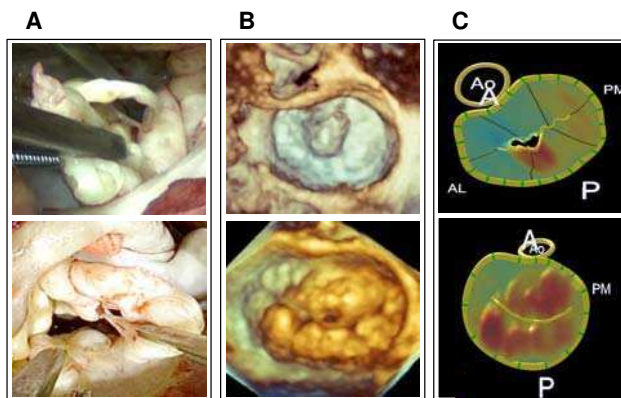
Examples of views of the mitral valve from the left atrial perspective obtained in two patients with degenerative mitral valve disease: (top) fibroelastic deficiency with a P2 flail leaflet and ruptured chords, and (bottom) Barlow's disease with multi-segmental billowing: (A) surgical views, (B) zoomed 3D echocardiographic views, and (C) corresponding 3D rendered color-coded images.
